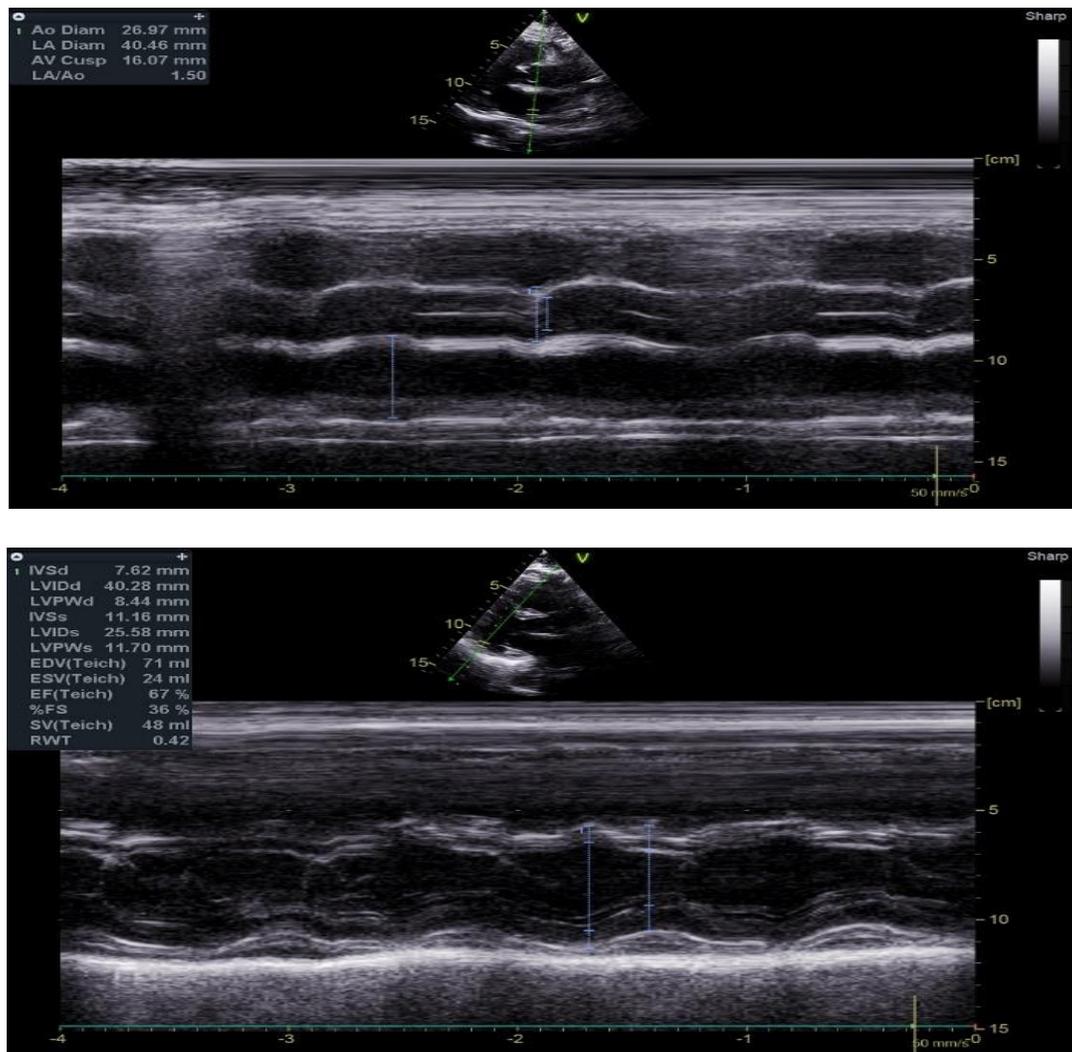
Echocardiogram showing regional wall motion abnormalities - hypokinesia of mid inferior wall, good left ventricular systolic function with LVEF – 60%; grade 1 diastolic dysfunction and valvular abnormality - Aortic Sclerosis
